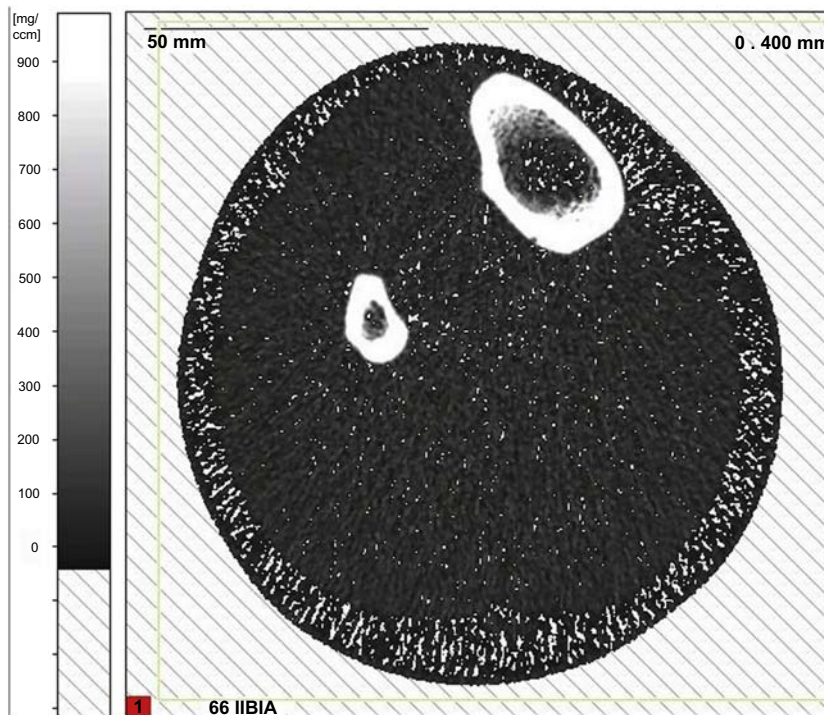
Peripheral quantitative computed tomography (pQCT) image of muscle, subcutaneous fat and bone at the 66% distal tibia.
